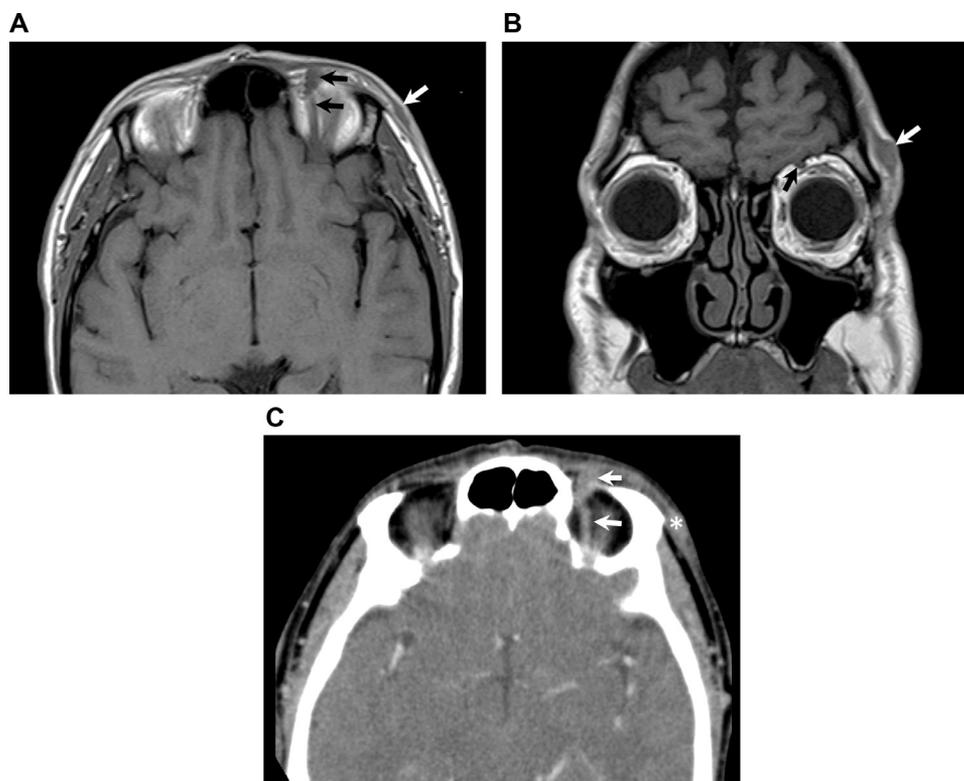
Perineural tumor spread from cutaneous squamous cell carcinoma along V1. (A) Axial T1 weighted image. There is a left temporal and upper eyelid cutaneous squamous cell carcinoma causing thickening of the left temporal subcutaneous tissue (white arrow) with perineural tumor spread to branches of V1 causing enlargement of the left supraorbital nerve (black arrows). (B) Coronal T1-weighted image without contrast. The ovoid left temporal cutaneous squamous cell carcinoma (white arrow) is well seen. Associate perineural tumor spread with an enlarged left supraorbital nerve (black arrow) is well seen against the background of T1 hyperintense normal orbital fat. (C) Axial contrast-enhanced CT. The left temporal subcutaneous thickening (white asterisk) from the cutaneous squamous cell carcinoma and the perineural tumor spread causing thickening of the left supraorbital nerve (white arrows) are also visible by CT.
